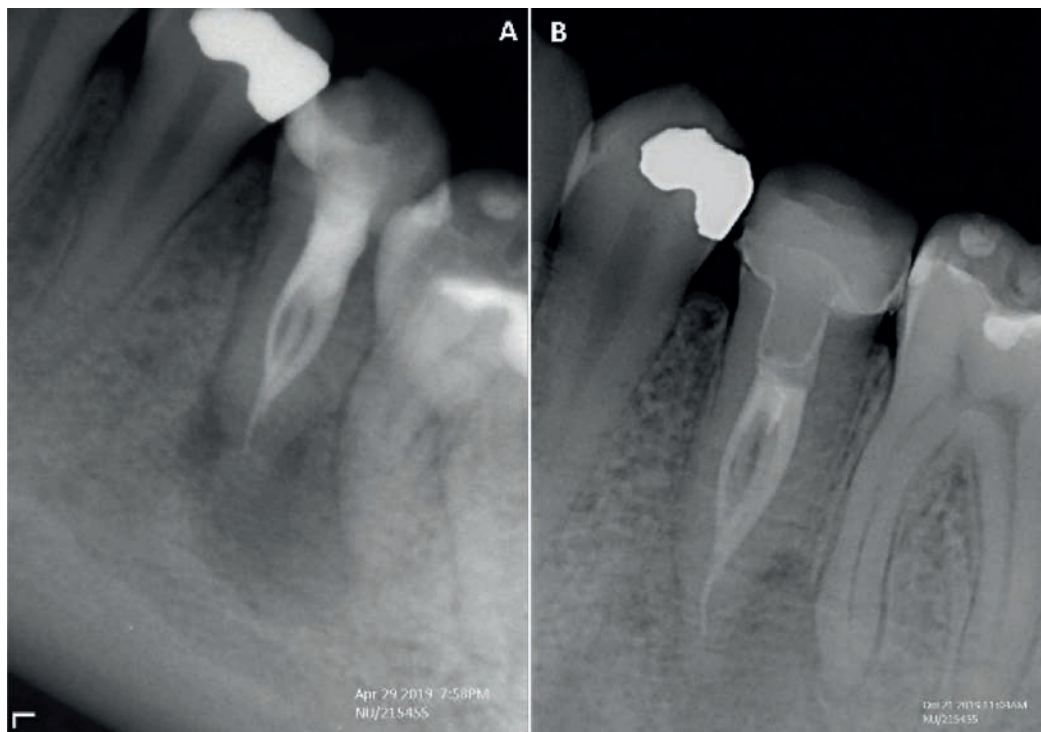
Follow-up radiographs showed the healing of the apical lesion: after 3 months (A), after 12 months (B)
